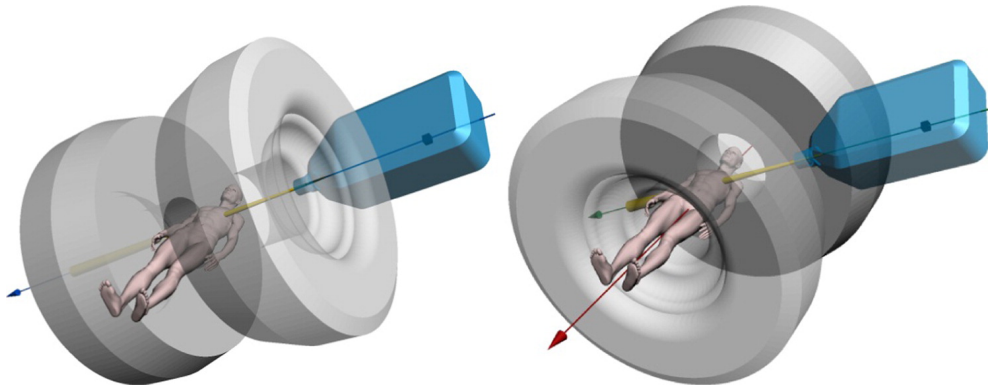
Visualisation of the Australian MRI-Linac showing both orientations to be experimentally investigated. (Left) Inline orientation, linac aligned with B_0 . (Right) Perpendicular orientation, linac perpendicular to B_0 [38].
